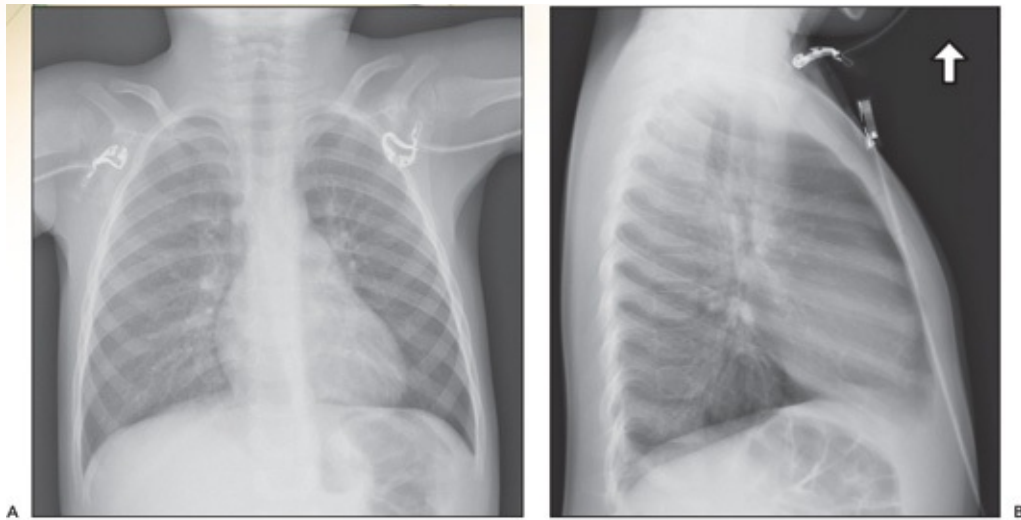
A: AP. B: Lateral chest radiographs demonstrating hyperinflation and peribronchial cuffing.
